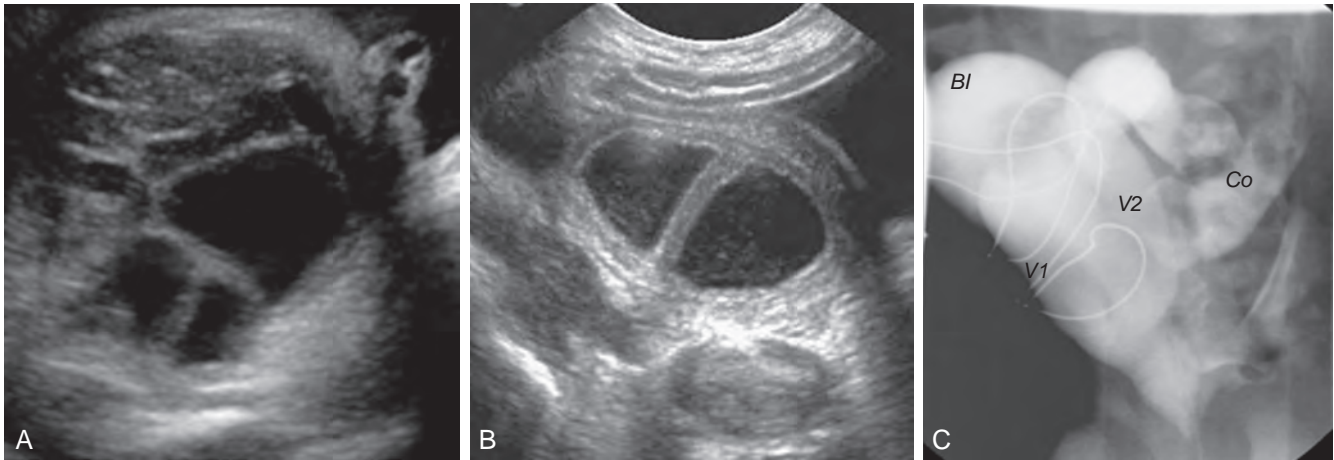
A, Prenatal sonogram performed for oligohydramnios in a 34-week female fetus demonstrating dual pelvic cystic structures below a dilated bladder. B, Postnatal sonography confirms the pelvic structures to be hemivaginas. C, Cystogram confirms the diagnosis of cloacal anomaly because the hemivaginas, dilated bladder, and distal colon are opacified with contrast medium injected into a single perineal opening. Bl, bladder; Co, colon; V1, hemivagina; V2, hemivagina.
